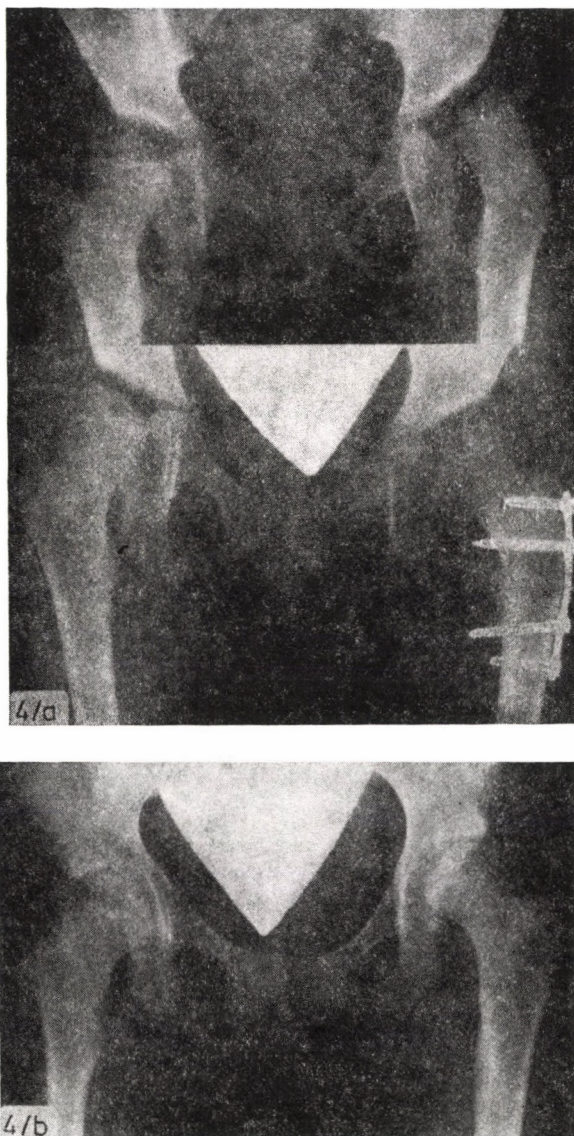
a. Open adductor tenotomy, open reduction of the hip, varus derotation femoral osteotomy. b. Roentgenogram made 5 years later
